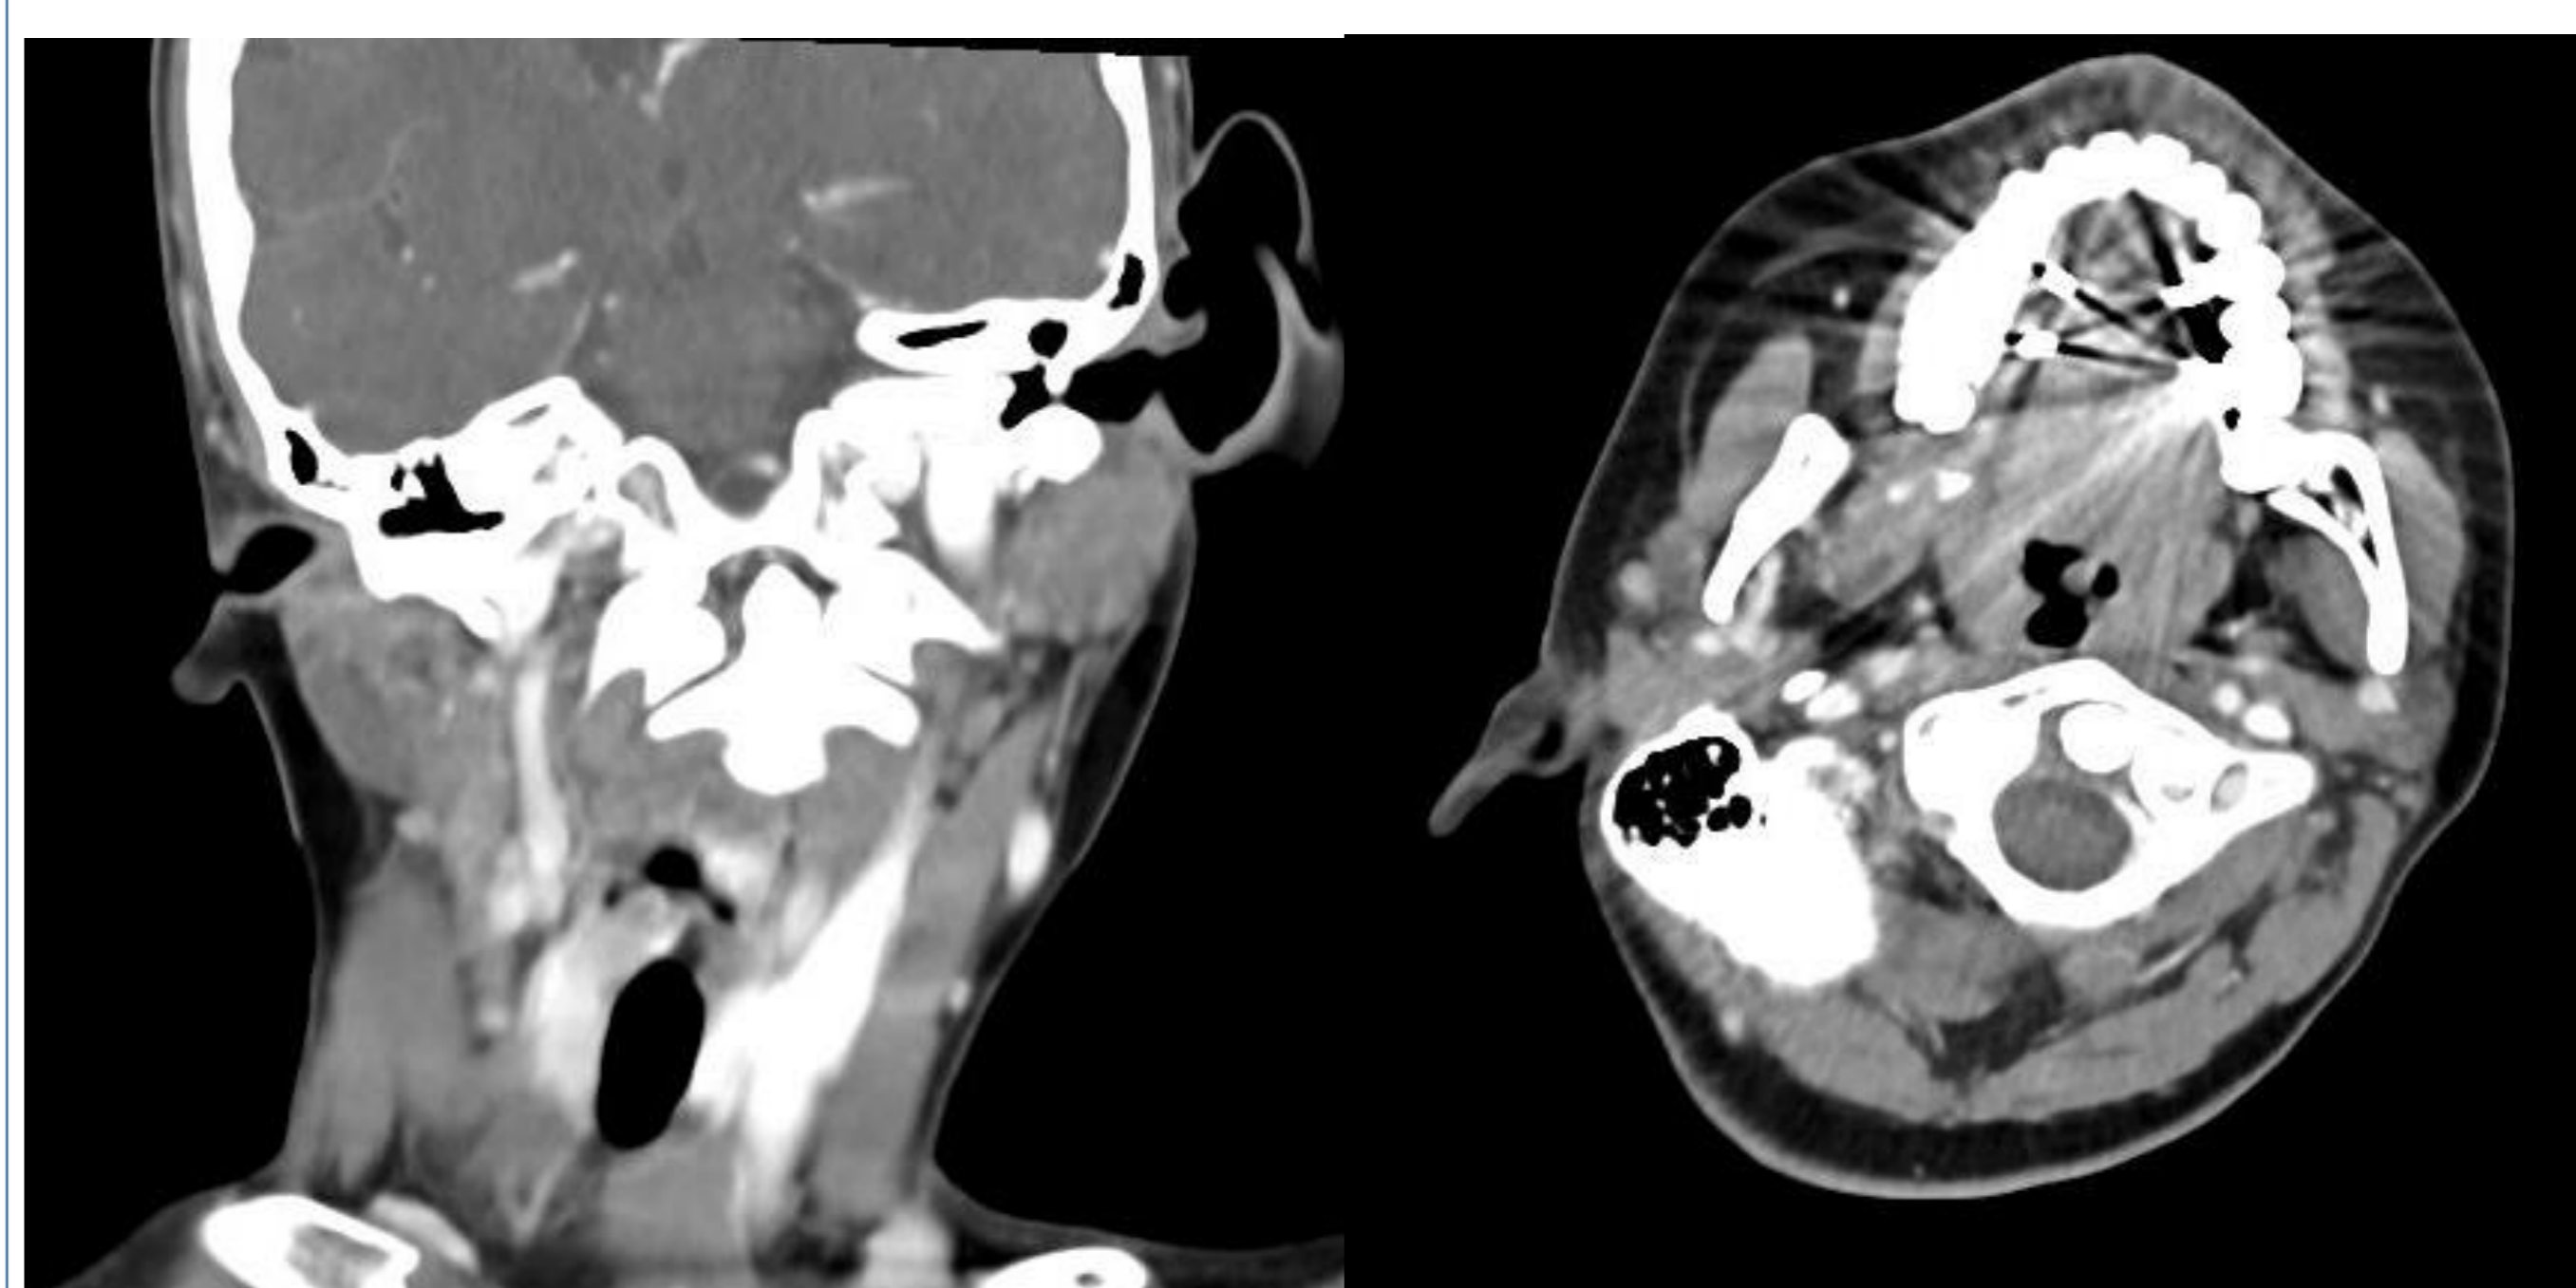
Axial and coronal computed tomography images demonstrate rotational malalignment of the atlas and axis, consistent with atlantoaxial rotatory subluxation.
